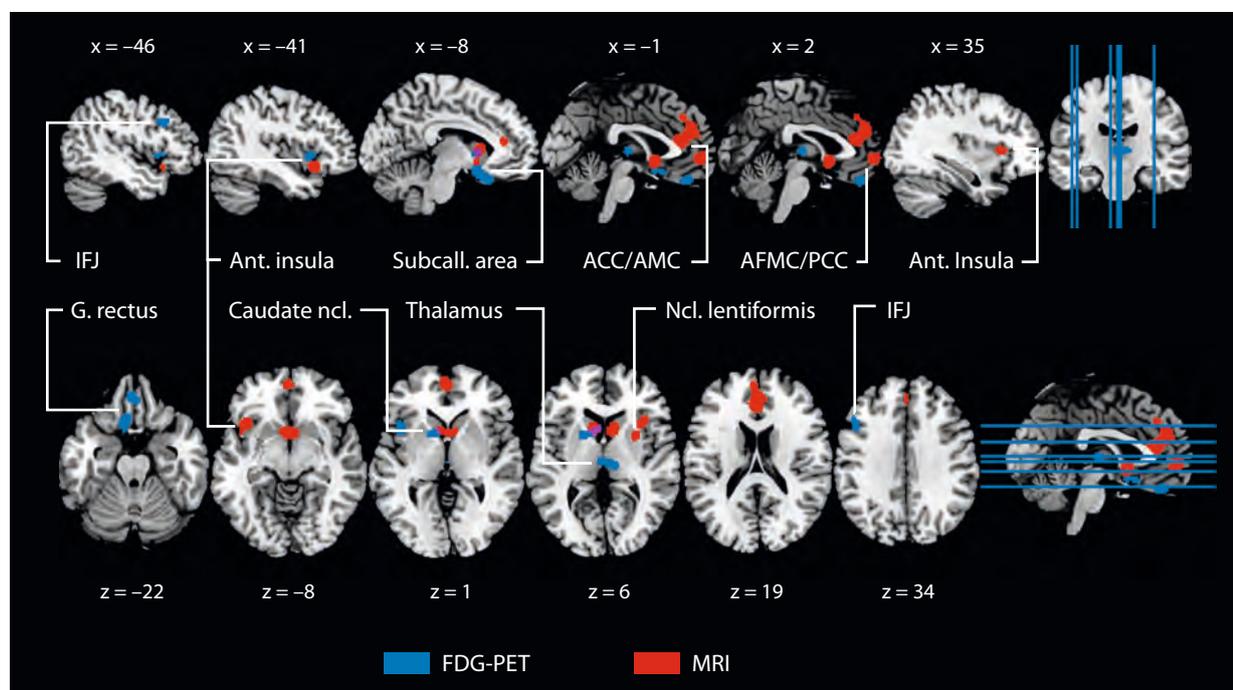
Impaired brain regions in bvFTD in comparison with healthy control subjects—anatomical likelihood estimates. Atrophy as measured by MRI red, hypometabolism as measured by FDG-PET blue, overlap pink. Nine MRI and 11 FDG-PET studies. Left is left. MNI coordinates. Acc. accumbens, ACC/AMC anterior cingulate and midcingulate cortex, AFMC/PCC anterior frontomedian/paracingulate cortex, Ant. anterior, FDG-PET 18F-fluorodeoxyglucose positron emission tomography, G. gyrus, IFJ inferior frontal junction, MNI Montreal Neurological Institute, MRI magnetic resonance imaging, Ncl. nucleus, Subcall. subcallosal.
